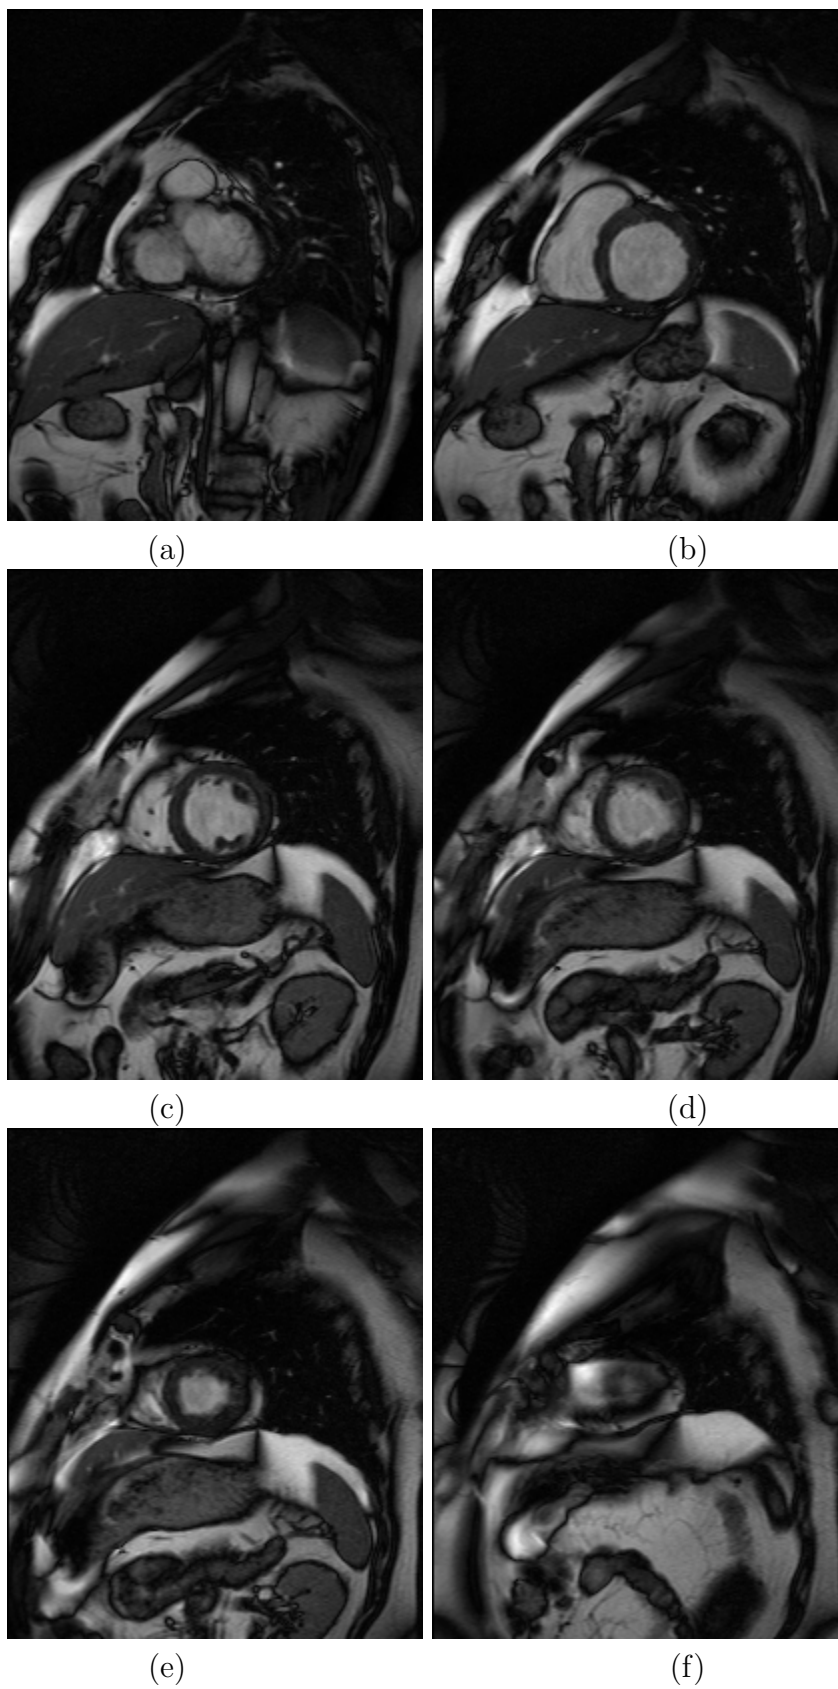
(a) - (f) cardiac MR images acquired at same time while different positions along the short axis of the heart
